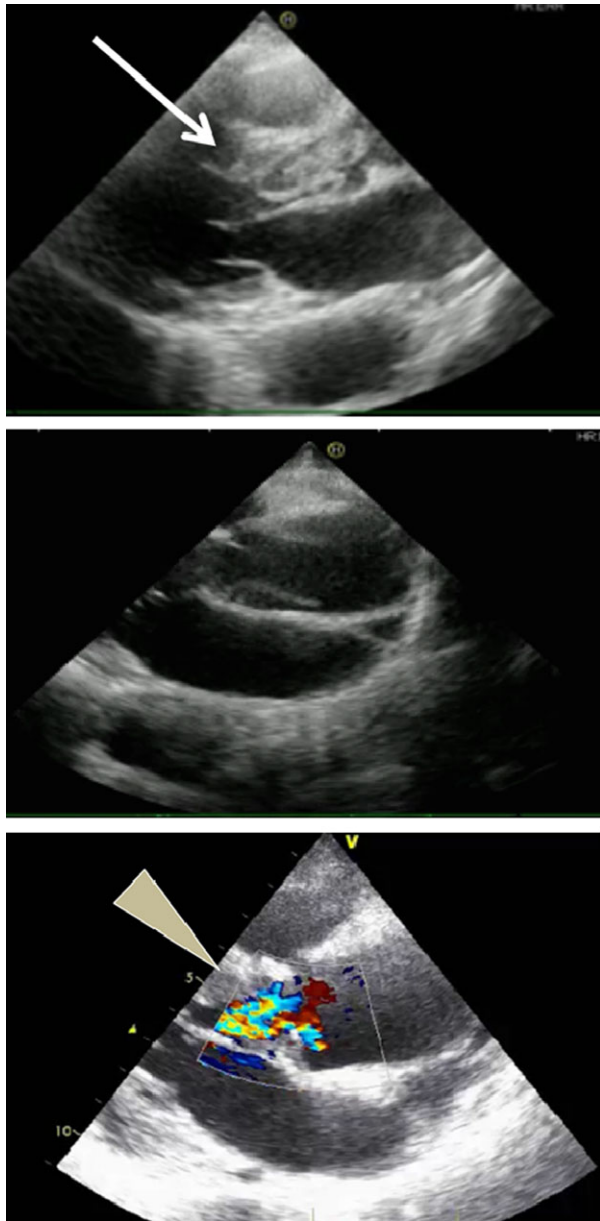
Echocardiograms of a 58-year-old woman with sudden-onset chest discomfort and loss of consciousness, showing an intimal tear at the ascending aorta and prolapse into the left ventricle (arrow), which caused severe aortic regurgitation during the diastole phase (arrowhead).
